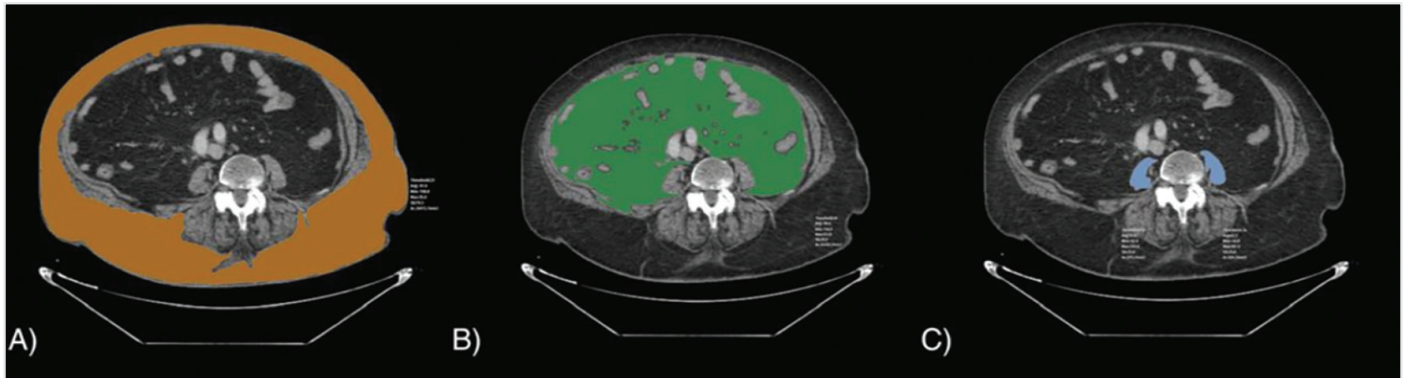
Computed tomography (CT)-based body composition analysis at the L3 vertebral level. Representative axial CT images showing semi-automatic segmentation of A) subcutaneous adipose tissue, B) visceral adipose tissue, and C) bilateral psoas muscles. Subcutaneous and visceral adipose tissue compartments were segmented using a predefined attenuation threshold range of -190 to -30 HU, followed by manual correction. All panels depict different tissue segmentations derived from the same axial CT slice of a single patient
